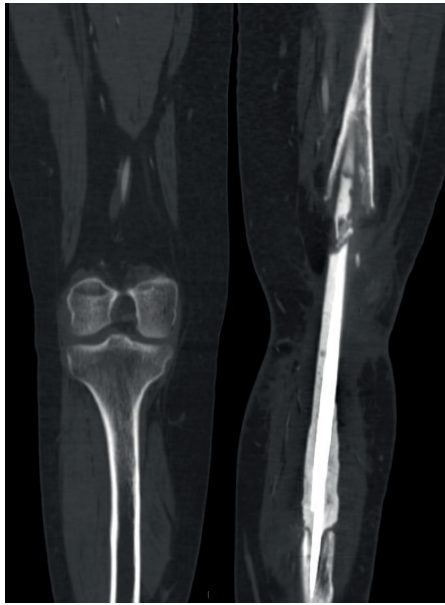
CT coronal section which show the PMMA custom-made spacer.
